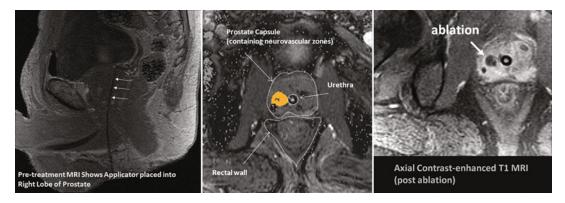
MR guidance and thermometry for laser ablation: Sagittal (far left and far right) and axial (central) MR images during prostate ablation show 1.6-mm OD laser probe (Visualase Inc., Houston Texas) in place (left). Colorized thermal monitoring during ablation
